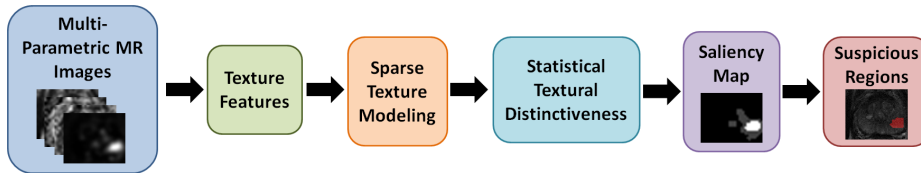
Proposed framework for identifying suspicious regions using prostate multi-parametric MRI. Unique texture features extracted from different MRI modalities are used to learn a sparse texture model, and suspicious regions are identified via a statistical textural distinctiveness-based saliency map.
